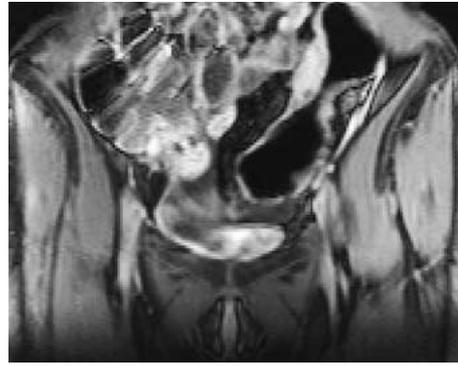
A 45-year-old female with longstanding UC of the left colon (30 years) who complained of worsening symptoms and lower abdominal pain. Coronal T1-weighted post-gadolinium image demonstrates marked eccentric wall thickening of the sigmoid colon that produces a tight stricture and is strongly suggestive of carcinoma. This finding was confirmed at endoscopy and surgery.
